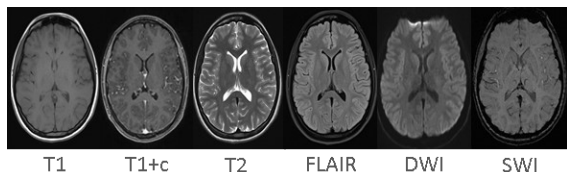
Non-perfusion brain MRI sequences acquired during persistent FHM aura symptoms. c: contrast; FLAIR: FLuid-Attenuated Inversion Recovery; DWI: Diffusion-Weighted Imaging; SWI: Susceptibility-Weighted Imaging
